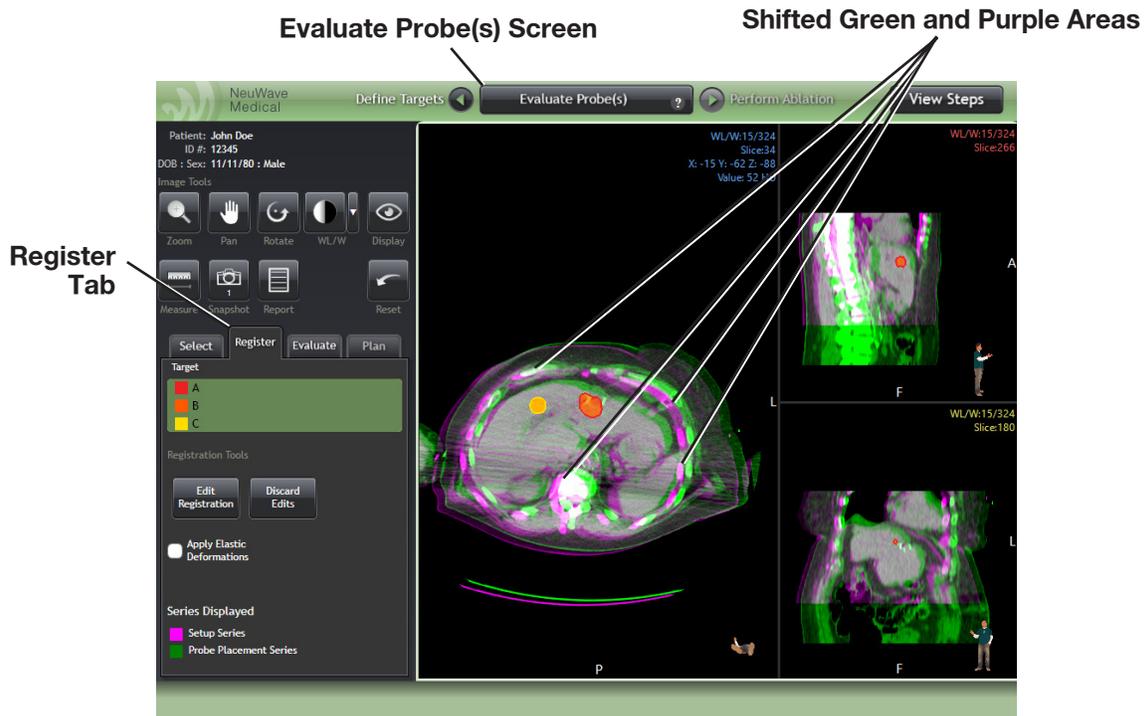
Evaluating Registration. Large areas in green and/or purple indicate that a significant shift has occurred between the Setup CT Series and the Probe Placement CT Series.
